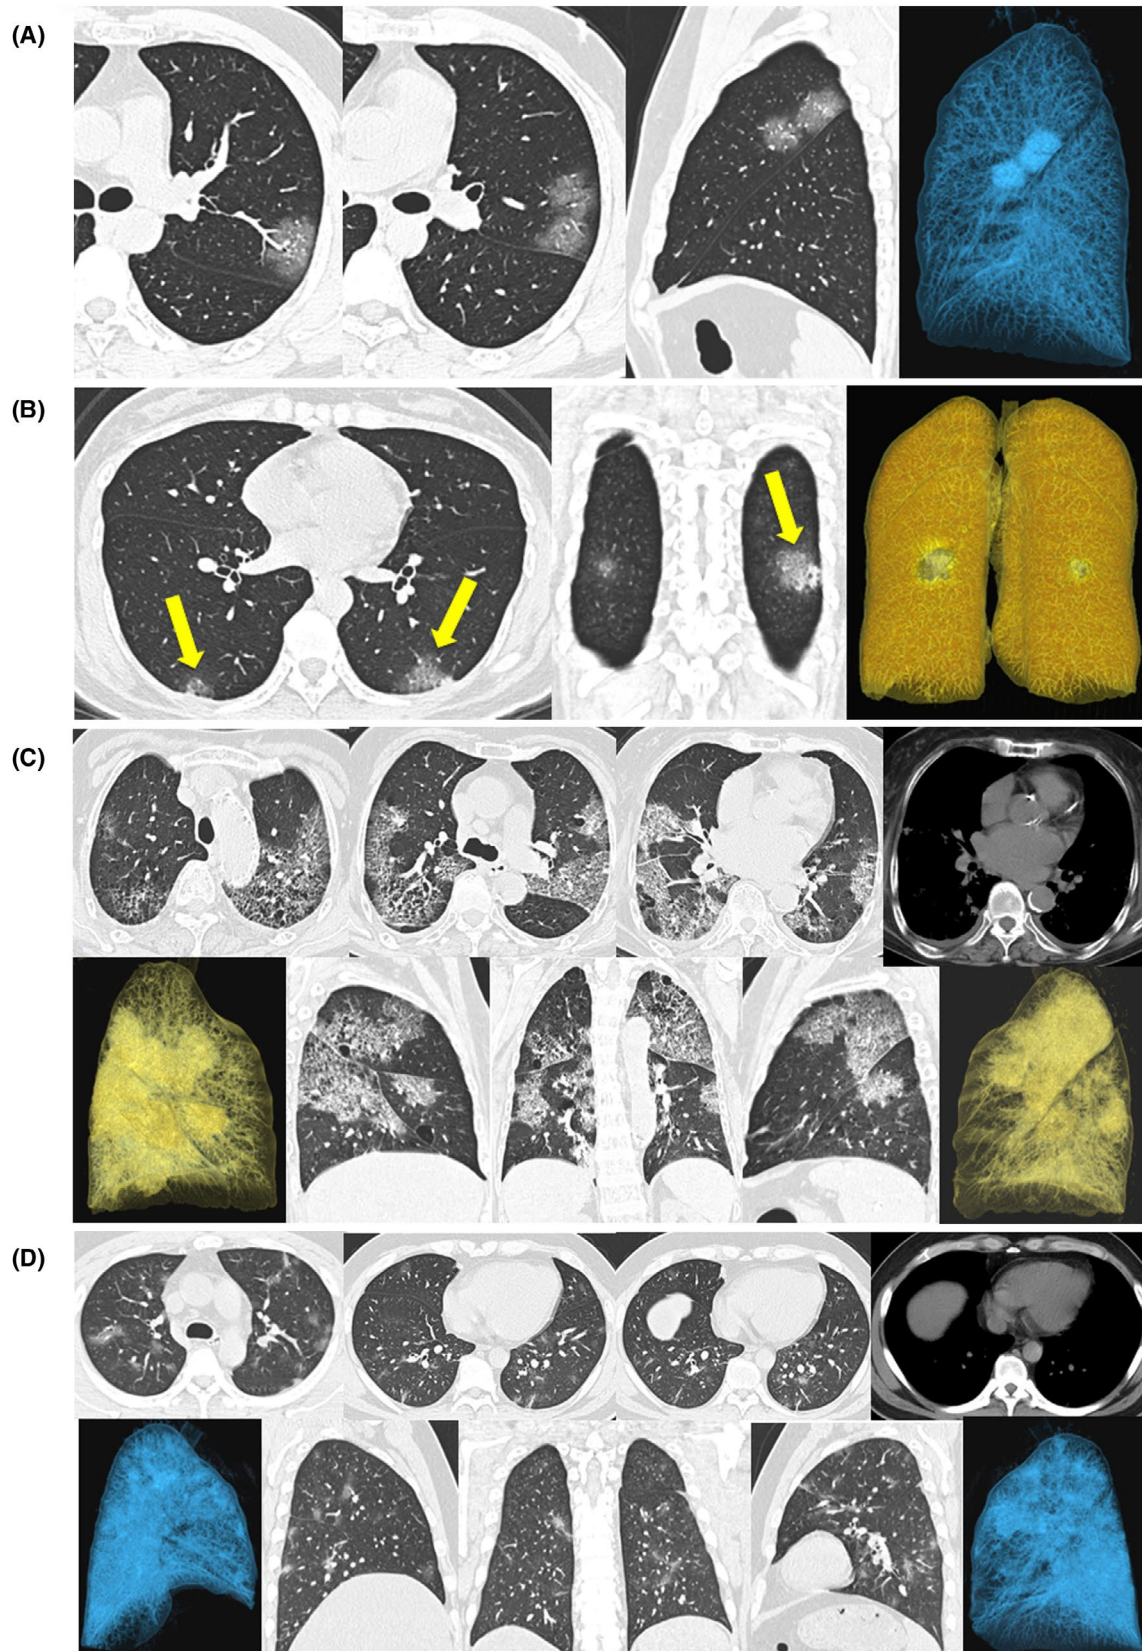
Transverse thin-section CT scan for the moderate patients of Covid-19. A, a 36-year-old male was admitted to the hospital because of cough for four days and fever for half-day and diagnosed as moderate of Covid-19. CT demonstrated pure ground-glass opacity in the left superior lobe. The lobular involvement score was one point, with the lobe involved less than 25%. B, a 36-year-old female was admitted to the hospital because of fever for 3 days, and diagnosed as moderate of Covid-19. CT revealed a subpleural confounding opacity lesion in the lower lobe of the left lung, and a patchy ground-glass opacity lesion with blurred boundaries in the lower lobe of the right lung (yellow arrows). The lobular score was one each in the left inferior lobe and the right inferior lobe, respectively, because of the involved area less than 25%. C, An 80-year-old female was admitted to the hospital because of diarrhoea, dyspnoea, anorexia, fatigue and muscular soreness, no fever or cough and diagnosed as severe of Covid-19. CT on admission showed diffuse lesions, mainly ground-glass opacity accompanied by partial consolidation, crazy-paving pattern in bilateral lungs, which were chiefly distributed under the pleura. The total lobular involvement score was 11, with two in the left superior lobe, two in the left inferior lobe, two in the right superior lobe, two in the right medial lobe and three in the right inferior lobe. The patient was also with atherosclerosis of aorta and coronary artery and a small amount of effusion in bilateral pleura. D, a 36-year-old male was admitted to the hospital because of generalised fatigue, muscular soreness for four days, and fever for three days, and diagnosed as severe of Covid-19. CT on admission indicated diffused irregular mixed patchy and ground-glass opacity lesions in bilateral lungs. The total lobular involvement score was 14, with three in the left superior lobe, three in the left inferior lobe, three in the right superior lobe, two in the right medial lobe, and three in the right inferior lobe
